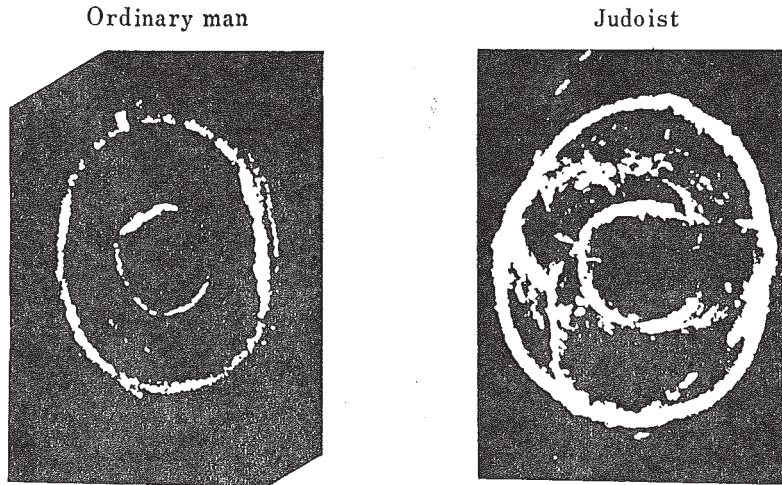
Ultrasonic View of Human Upper Arm
